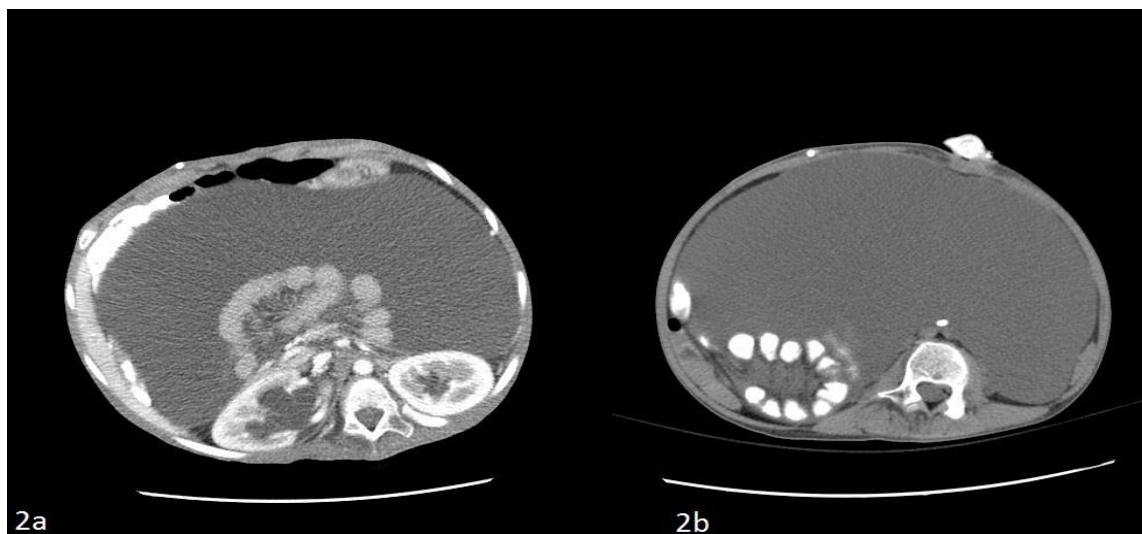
CT scan with contrast demonstrates (a) centralization of the small bowel with bilateral hydronephrosis and (b) displacement of the large bowel to the anterior abdominal wall
